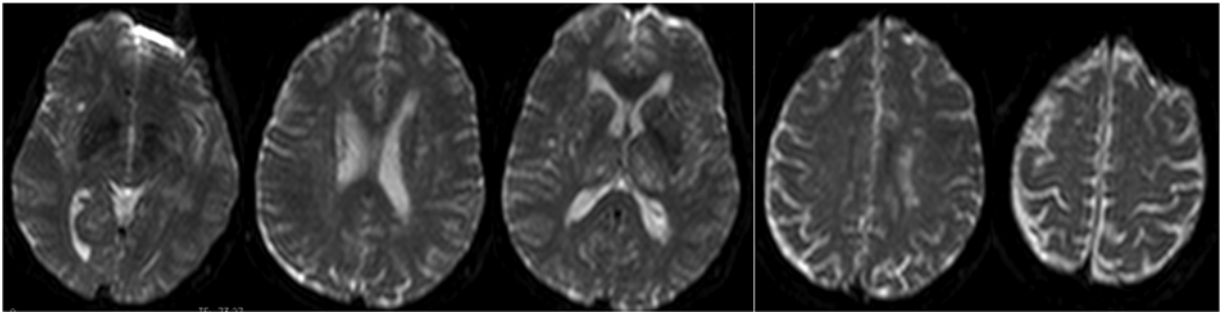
Brain magnetic resonance imaging performed 12 hours after intervention
